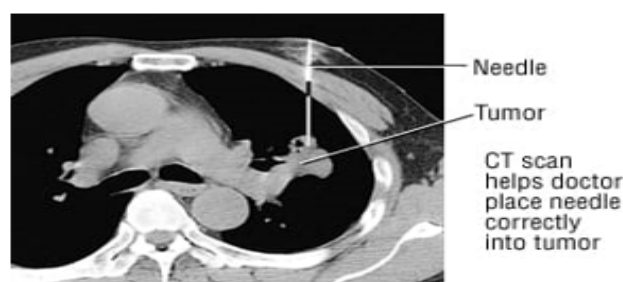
CT Scan of Lung Cancer.
